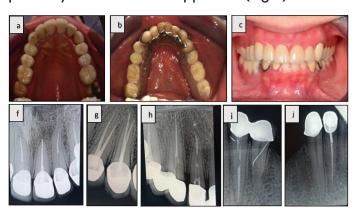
showing: (a) The postoperative occlusal view of maxillary arch. (b) The postoperative occlusal view of mandibular arch. (c) The postoperative frontal view. (d) The postoperative left lateral view. (e) The postoperative right lateral view. (f) the follow-up radiographs for teeth #11, #21 and #22. (g) Tooth #25. (h) Teeth #12 and #13. (i) Teeth #33 and #34. (j) Tooth #43.
